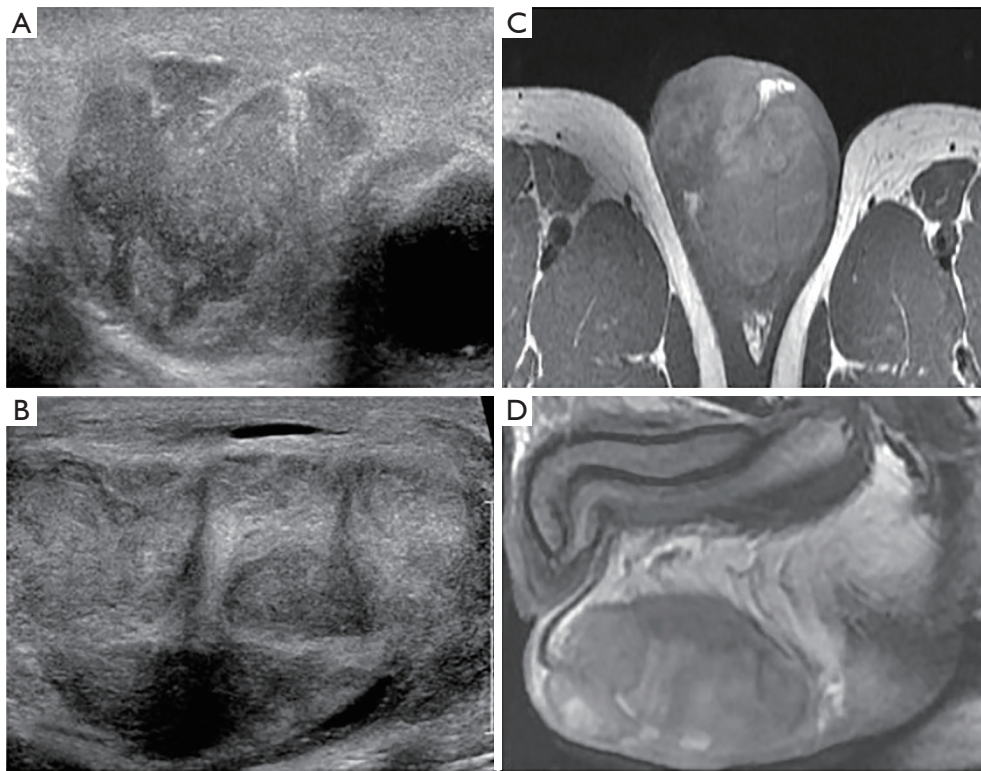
A 56-year-old male presented with left sided painful scrotum mass. (A) Longitudinal ultrasonic image shows nodular enlargement of the entire epididymis. (B) Nodular enlargement is also observed in testis. (C) T1WI in axial plane shows bilateral lesions in both sides of testes. (D) T1WI in sagittal plane shows an enlarged left testis with a heterogeneous mass with separation.
